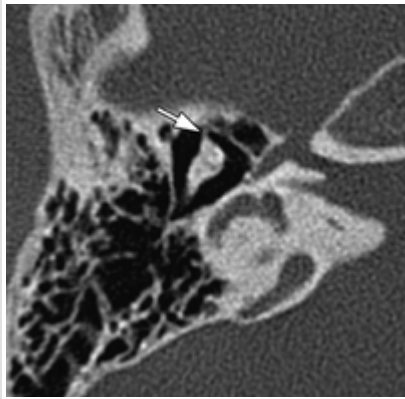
Transverse multi-detector row CT scan of a normal right temporal bone. Anterior malleal ligament (arrow) is shown.
